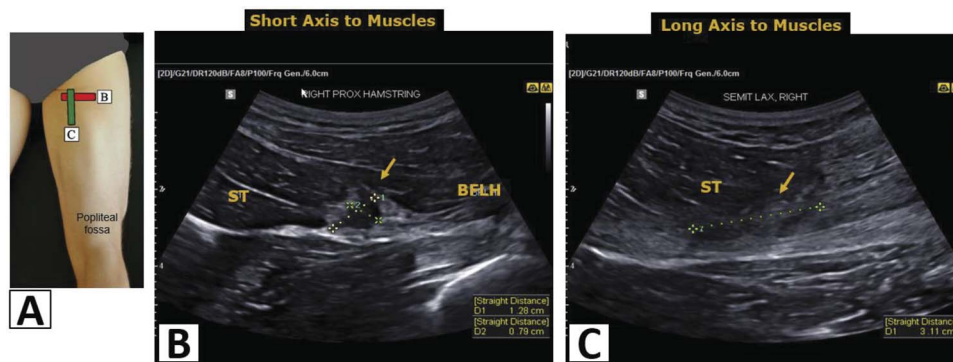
Proximal semitendinosus (ST) injury—athlete Z. A, Transducer position for B and C. B, Short axis sonographic image of the proximal hamstrings demonstrating a 1.28 × 0.79-cm tissue defect. C, Long axis ultrasound image demonstrating a 3.11-cm tissue defect. Abbreviation: BFLH, biceps femoris long head.
